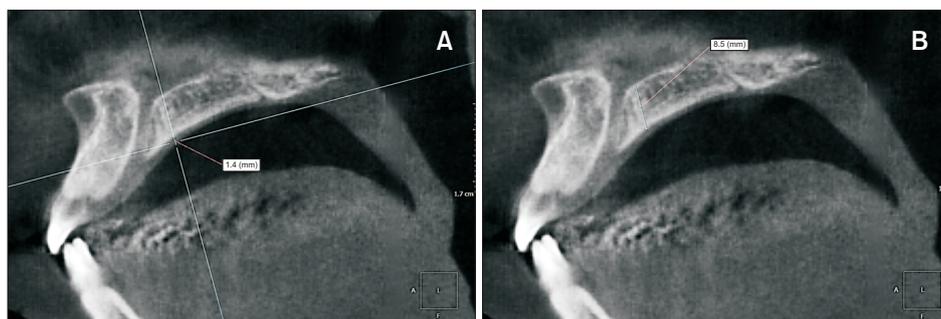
A sagittal section of a cone-beam computed tomography image of the palate. The image shows the measurement of the height of the soft (A) and hard (B) tissues of the palate at one reference point (the midpalatal suture [ML = 0], 4 mm from incisive foramen posteriorly [AP = 4]). AP, anterior-posterior; ML, midline-lateral.
